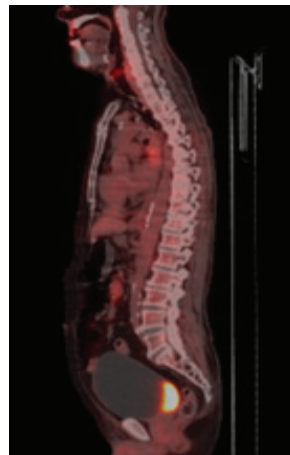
(b): Figure 1(b): PET-CT fused image in sagittal section showing Posterior layering of UB
